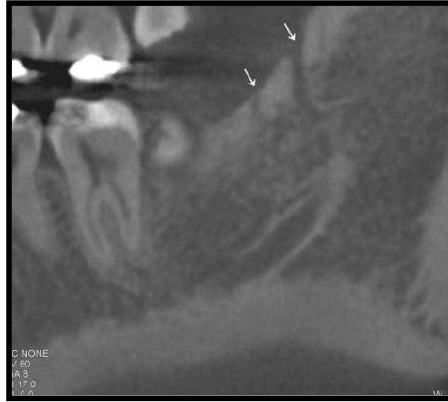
CBCT image shows canal type 5A (trifid canal type: two accessory canals of the retromolar canal type)
